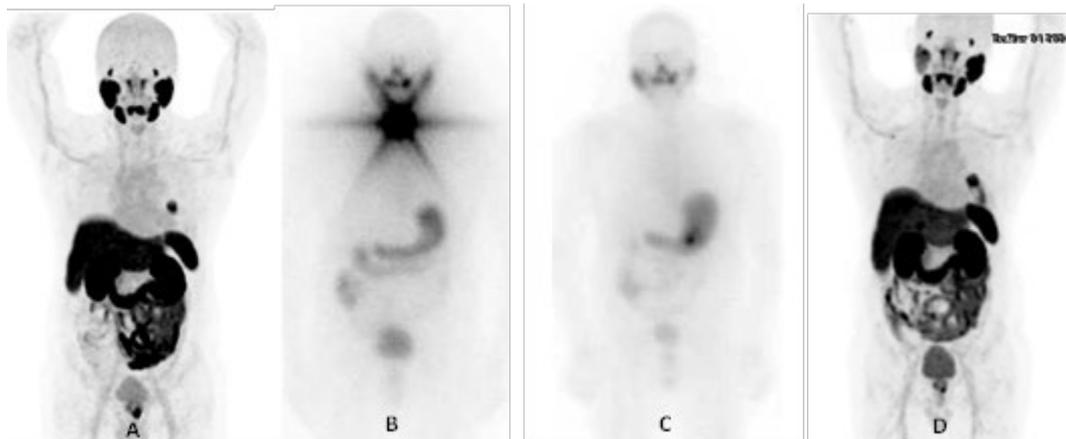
A) PSMA receptor-overexpressing lesions in the prostate and left lower lung nodule B) Functioning thyroid tissue remnants in the anterior neck with a non-iodine-avid left lung nodule and C) Successful ablation of the neck remnants and persistent non-radioiodine concentration of left lung nodule. D) Interval decrease of PSMA receptor-overexpressing lesions in the prostate while stable PSMA uptake in the lung nodule.
